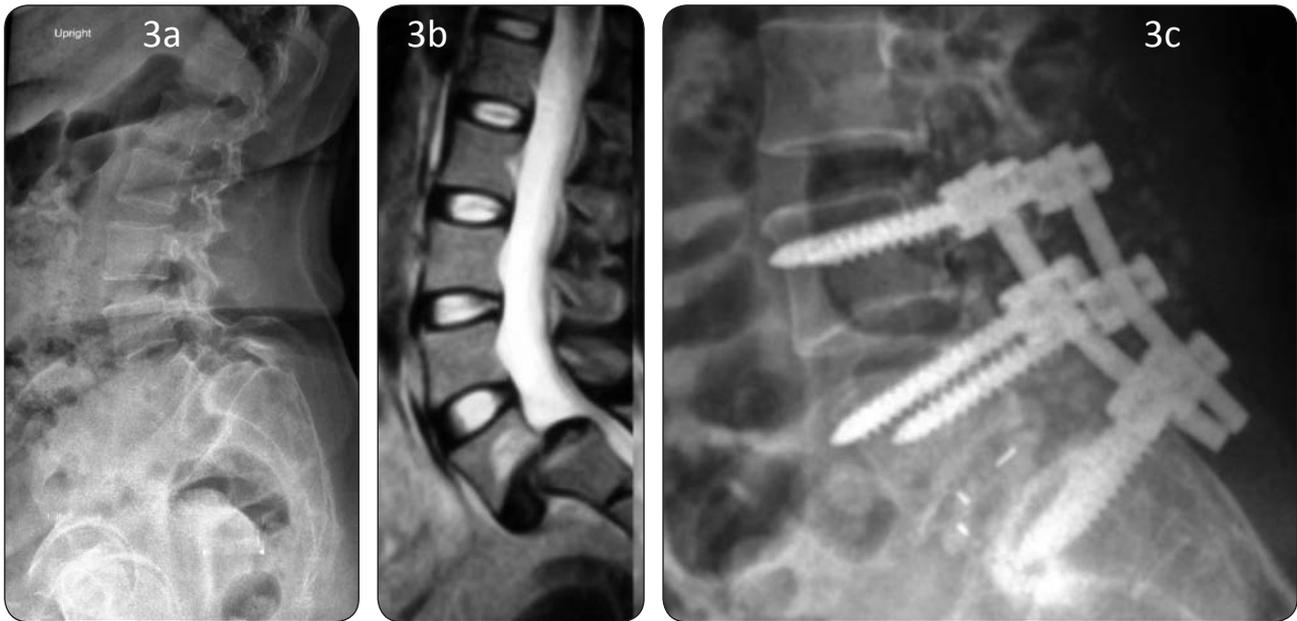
GA, 40 year old female. 3a. Preoperative lateral view with 78% slip, LSA 12, SS 48, PT 30 and PI 78. 3b. Preoperative sagittal T2 MRI. 3c. Postoperative lateral view with 13 % slip, LSA -12, SS 54, PT 25 and PI 79. At her latest follow up she experiences occasional low back pain but no leg pain. Takes occasional NSAIDs. Satisfied with her surgery and continues with her regular work as a school teacher.
